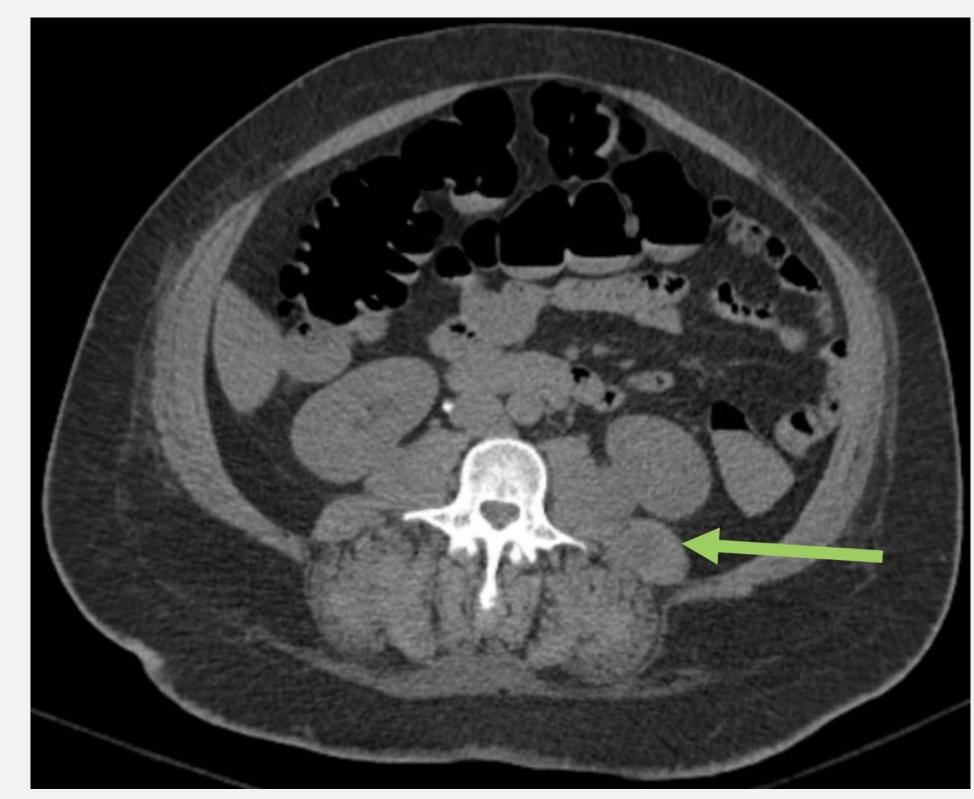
CT Abdomen and Pelvis
